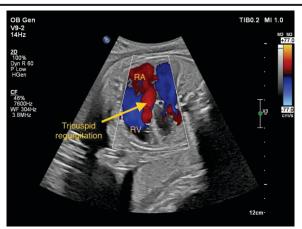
Image B -Colour Doppler showing jet of blood across the tricuspid valve during ventricular systole.
